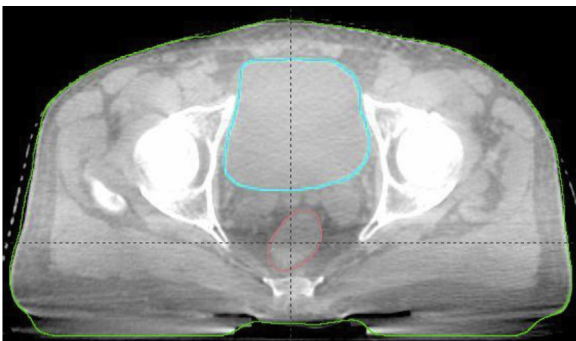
CBCT image of one of the cases having delineated bladder and rectum.
